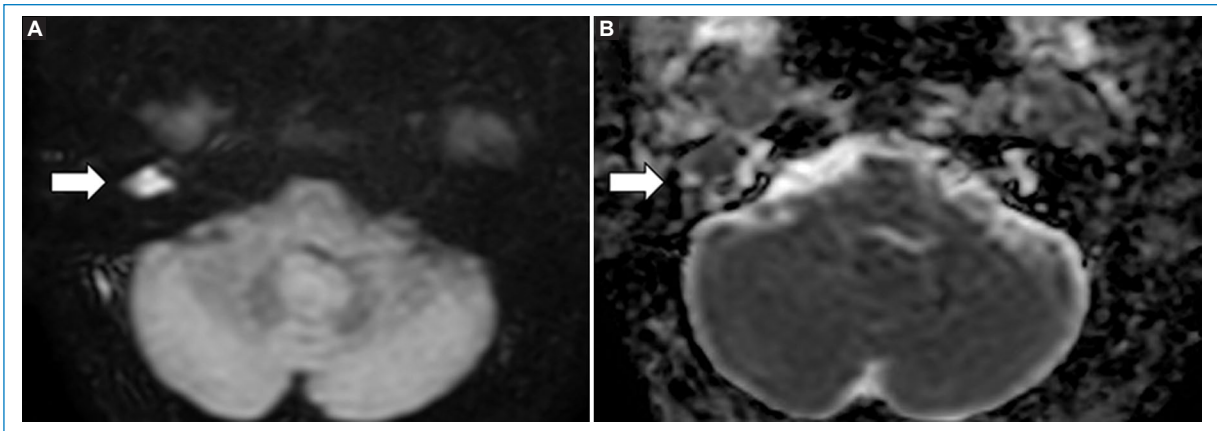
Phillips 1.5T TSE Axial MultiVane Diffusion. A lesion (A: DWI; B: ADC map) exhibiting restricted diffusion, consistent with a middle ear cholesteatoma in the epitympanum, is delimited (arrows).
